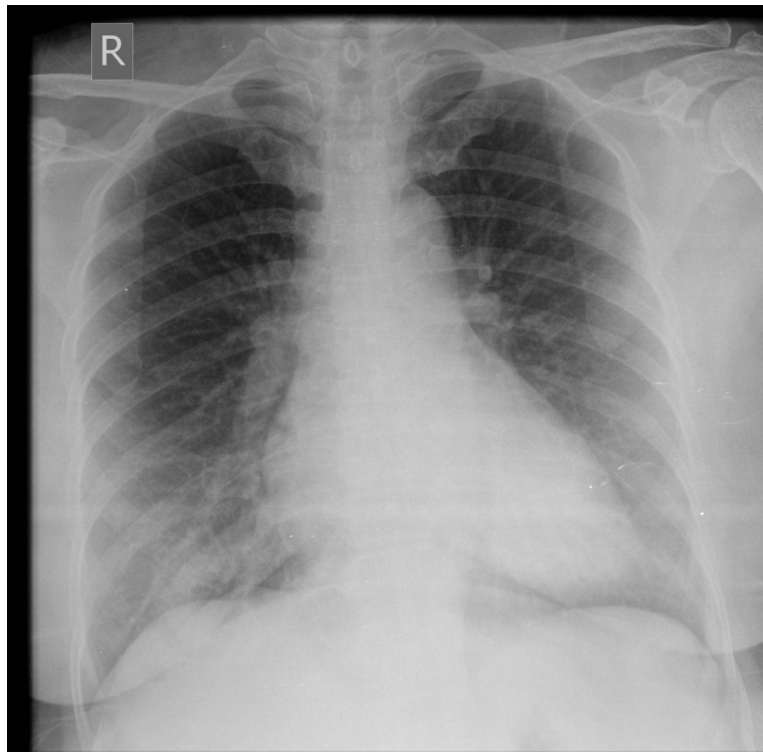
Chest X-ray frontal projection at day of presentation.
